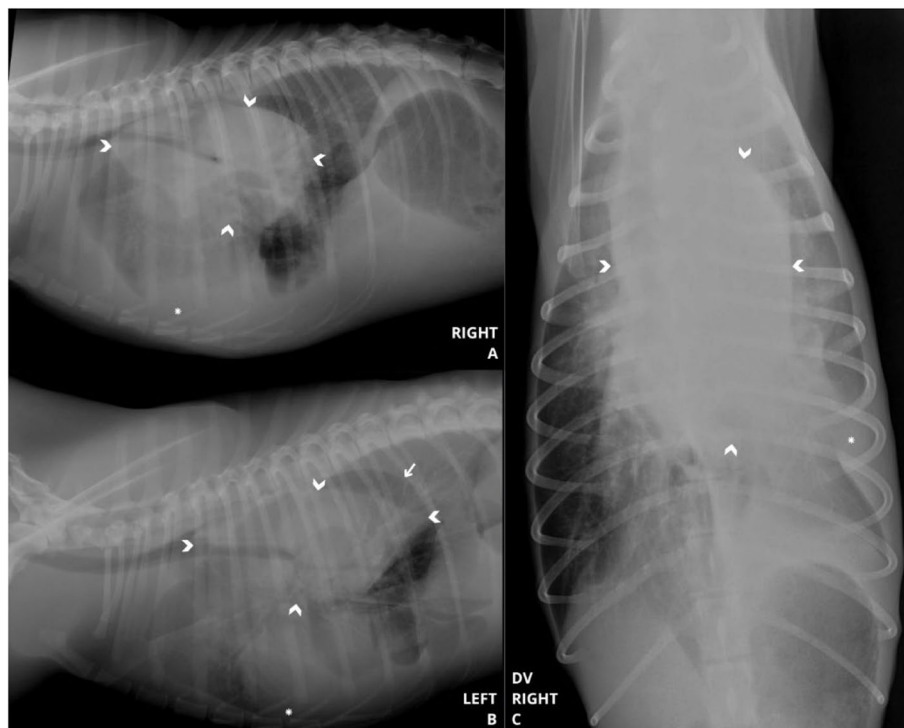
Thoracic radiographic examination in right lateral (A), left lateral (B), and dorsoventral (C) projections. Increased soft tissue radiopacity is observed in the dorsal aspect of cranial and middle mediastinum (arrowhead) with a mass effect. There is displacement of the thoracic trachea to the right, with dorsal deviation of its cranial portion and ventral deviation of its pre-terminal portion. The esophagus is visible in its cranial portion due to slight distension by gas content, displaced dorsally (arrow). Additionally, the presence of pleural effusion (*) is noted. DV = dorsoventral
